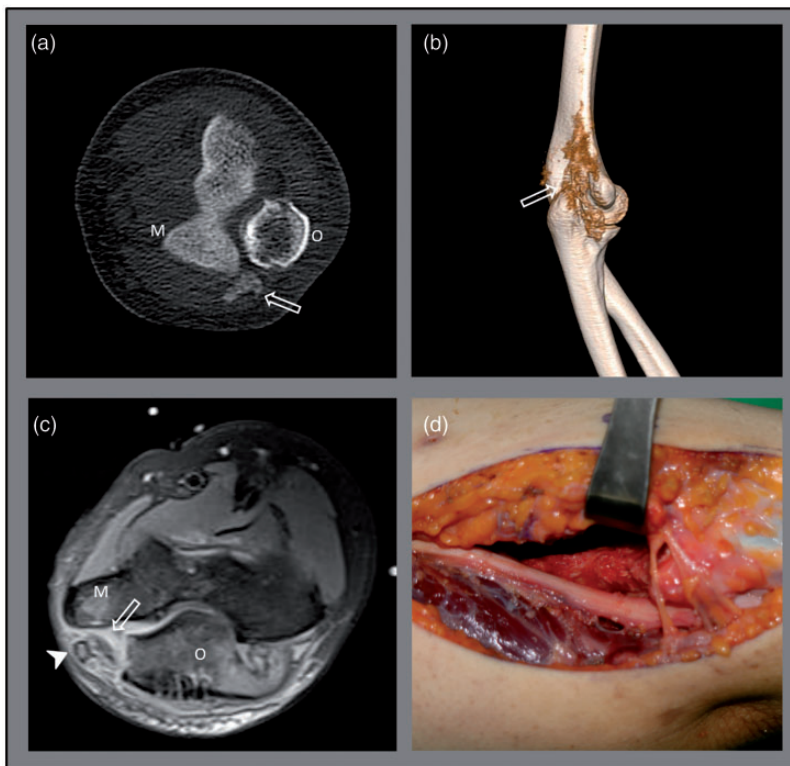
(a) Computed tomography showed ossification of a central slightly hypointense lesion (open arrow) with peripheral calcification between the medial epicondyle and olecranon. (b) Three-dimensional reconstruction of the left elbow computed tomography image revealed myositis ossificans (MO) (open arrow) located around the distal humerus, medial aspect of the olecranon process, and medial epicondyle. (c) Fat-suppression T2-weighted magnetic resonance imaging revealed a slightly heterogeneous, hyperintense lesion inducing superficial displacement and high signal change of the ulnar nerve (arrowhead). These findings demonstrated that the compression of the ulnar nerve was caused by MO (open arrow). (d) Intraoperative findings confirmed compression and outward displacement of the left ulnar nerve caused by MO.
